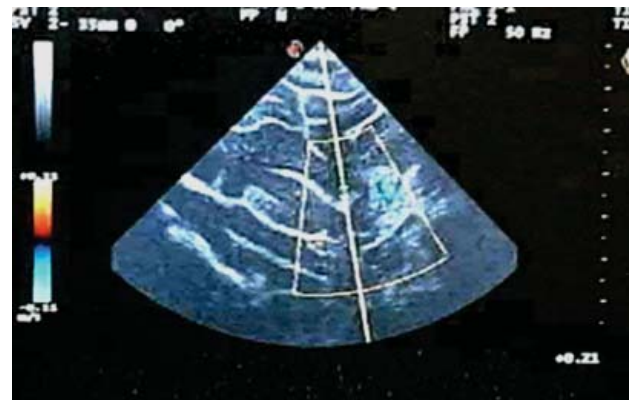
Ultrasound image showing (in blue) the pressure of the blood stream on the walls of the aneurysm, in addition to the anatomic details already described in the previous image.
